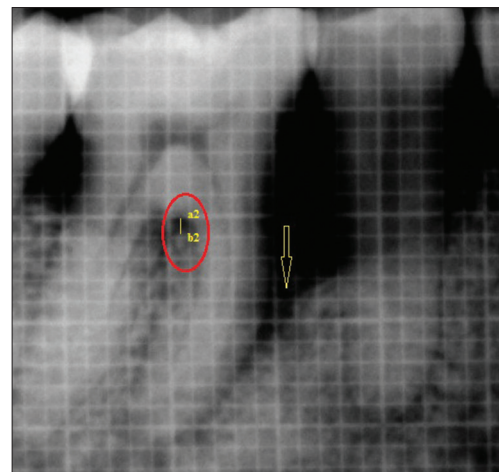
Six months postoperative radiograph showing almost complete furcation defect fill having vertical residual radiolucency of <0.5 mm (a2 and b2)
